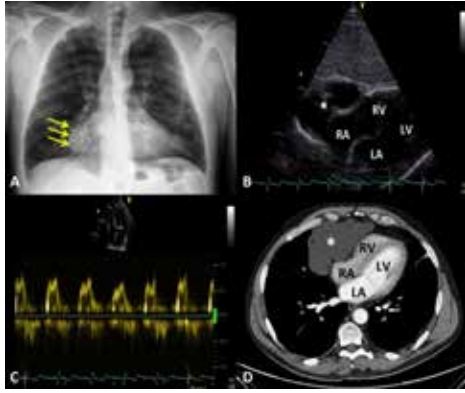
An elliptical mass adjacent to right ventricle (arrows, A). Pericardial cyst demonstrated with transthoracic echocardiography from subcostal view (star, B). Significant respiratory variation in mitral in-flow Doppler recordings (C). A contrast-free pericardial cyst located at the right cardiophrenic angle (D).
